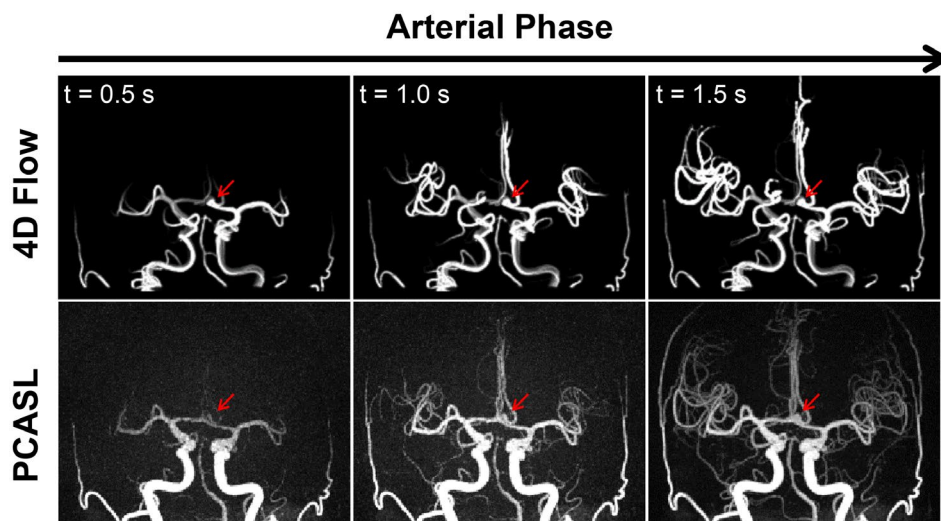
Comparison of virtual injections generated from improved streamlines from 4D-flow MRI and dynamic pseudo-continuous arterial spin labeling (PCASL) in a subject with an aneurysm in the anterior communicating artery (red arrow). Temporal frames for both data sets were matched, with arterial phase increasing from left to right. For both 3D images, data were projected along the coronal dimension. Note that signal intensities in the virtual injection images are directly proportional to the local streamline density at each specific time frame. Good qualitative agreement is seen between the two data sets
